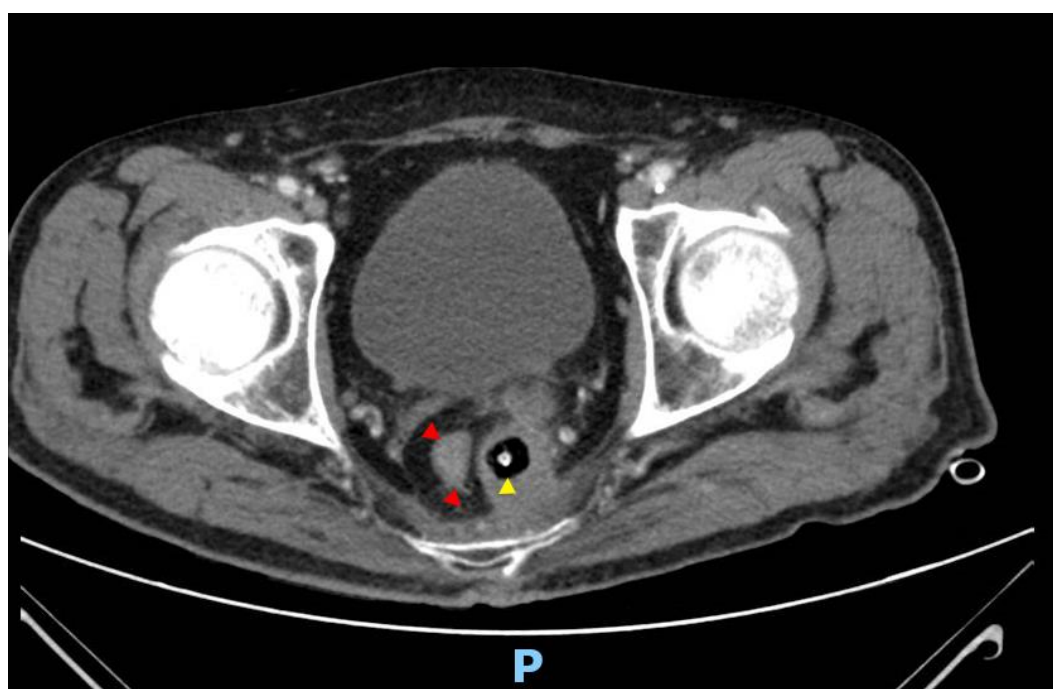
CT scan of the pelvis showing a peri-anastomotic collection, with presacral and left pararectal components, measuring 81 x 52 x 28 mm, with slight densification of the perirectal fat. Red arrows point to the contours of the rectum; yellow arrows show the peri-anastomotic collection, where a gas bubble is also visible.
